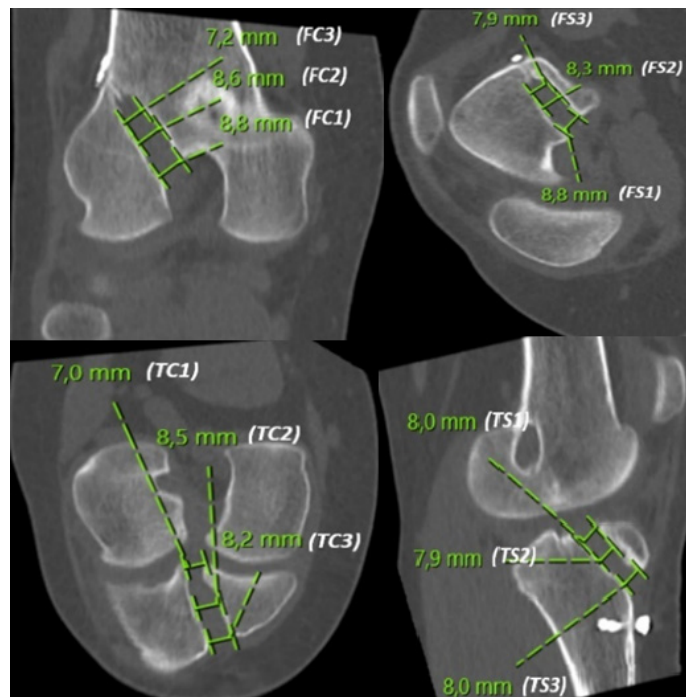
Measurement of tunnel diameter in CT imaging
